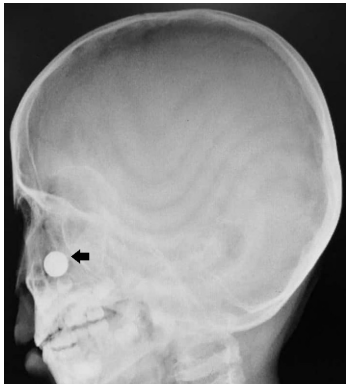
Lateral view of the paranasal cavity radiograph; a disc-shaped radio-opacity identified over the nasal region (arrow).
